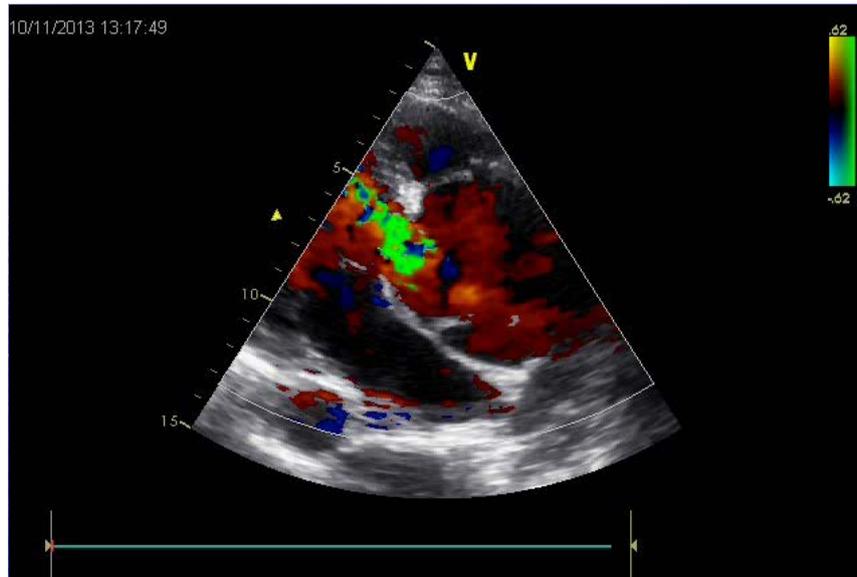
Colored Doppler showed Aortic regurgitation
